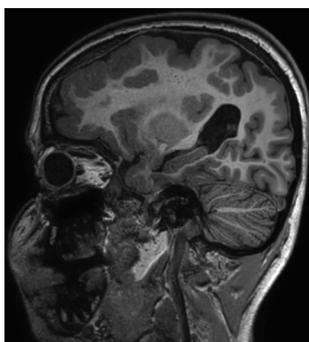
MRI scan, T1 weighted sequence in sagittal view showing multilobar polymicrogyria (sparing occipital lobe) (patient 17).
